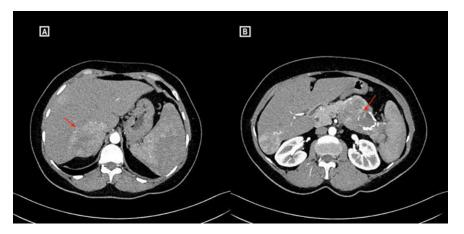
Findings on a CT Scan. Picture "A" shows multiple liver lesions enhancing on arterial phase consistent with metastasis. A large metastatic liver mass is shown by a red arrow. Picture "B" shows a large lobulated heterogeneously enhancing mass in body and tail of pancreas with calcifications, it is encasing and obstructing the splenic vein and compressing the adjacent proximal small bowel as indicated by a red arrow.
